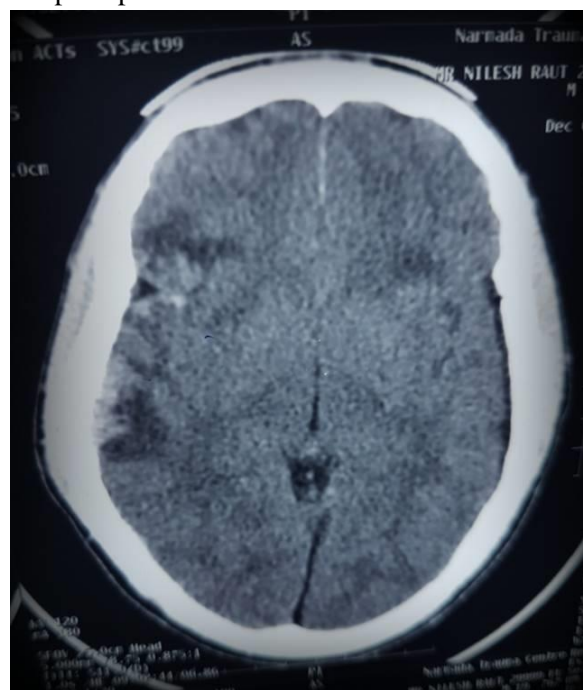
CT scan after 24 hours shows Right temporo-parietal contusion with edema.
